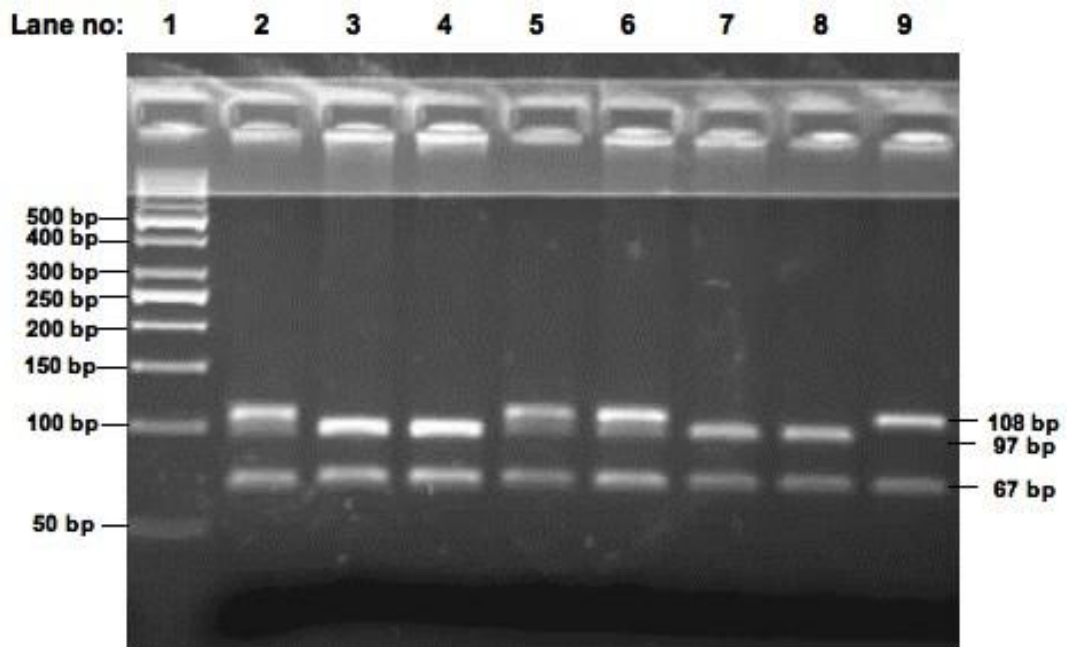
4 3% Nu-micropore agarose gel electrophoresis of *Hin* 6I digestion products for C59T SNP region of GABA_{B1}. First lane was loaded with DNA ladder (50-1000 bp), following lanes were loaded with digestion products of the subjects. Lane 2, 5 and 6 shows heterozygous genotype (CT) with 108-bp, 97-bp and 67-bp bands. Lane 3, 4, 7 and 8 show wild type genotype (CC) with 97-bp and 67-bp bands. Lane 9 shows polymorphic genotype (TT) with 108-bp and 67-bp bands.
